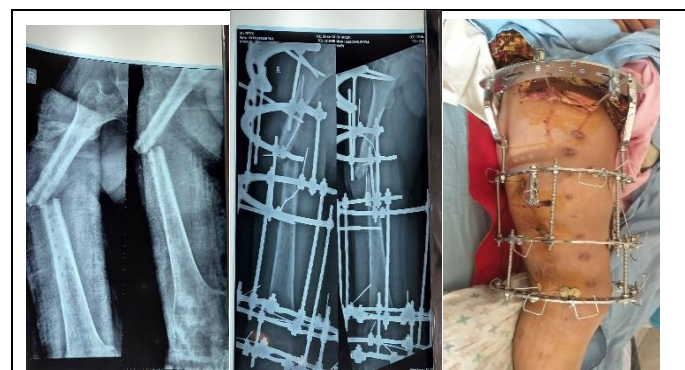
Pre-operative x-ray of thigh (B/V)
